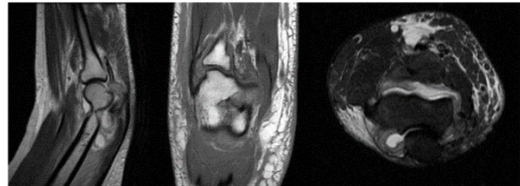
52 year old female patient with history of inability to completely flex the elbow since 8 days with swelling of the left elbow joint. MRI of left elbow joint reveals, Significant synovial thickening involving most of the capsule of the elbow joint; involving the humero-radial, humero-ulnar as well as radio-ulnar aspects. Minimal joint effusion.
